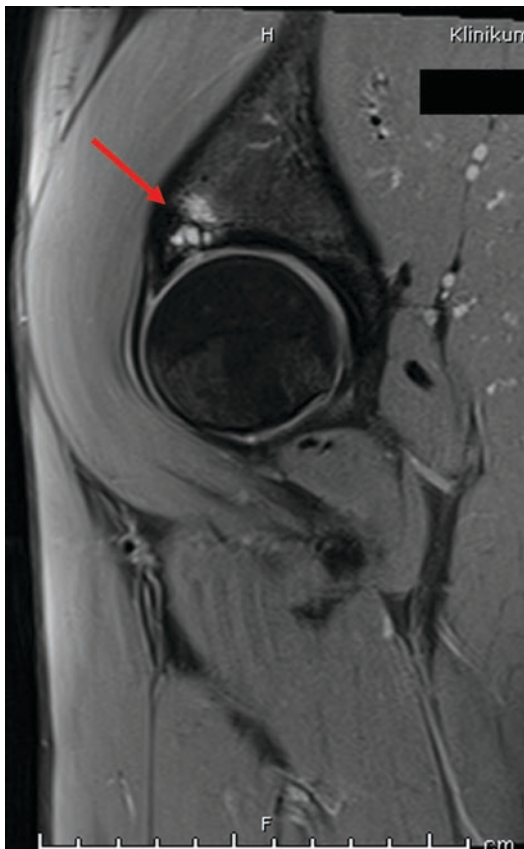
MRI of a labral lesion with acetabular roof cysts (see arrow) in femoroacetabular impingement
